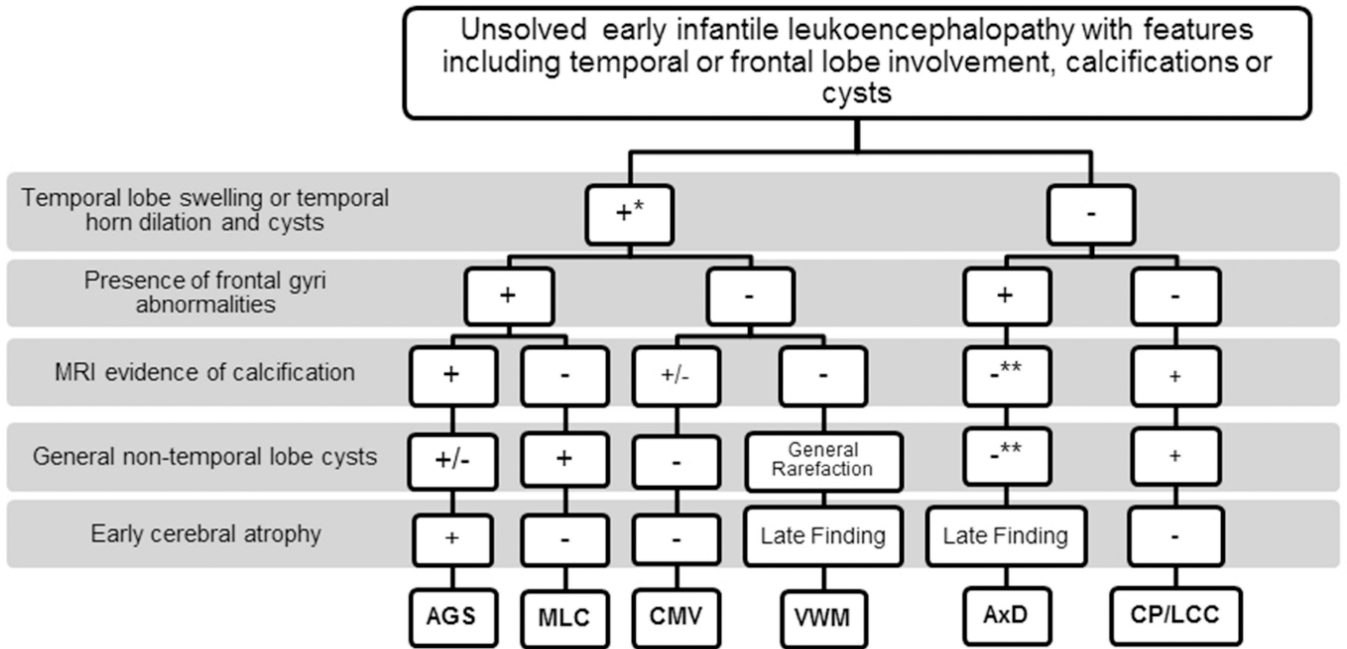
MRI characteristics of unsolved early infantile leukoencephalopathy
